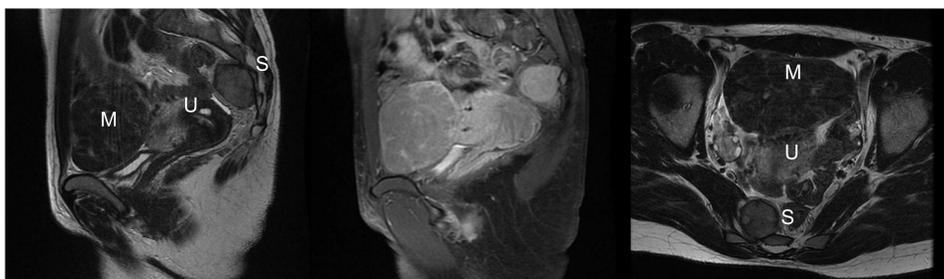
Abdomino-Pelvic MRI. S: Schwannoma. U: uterus. M: mioma.
